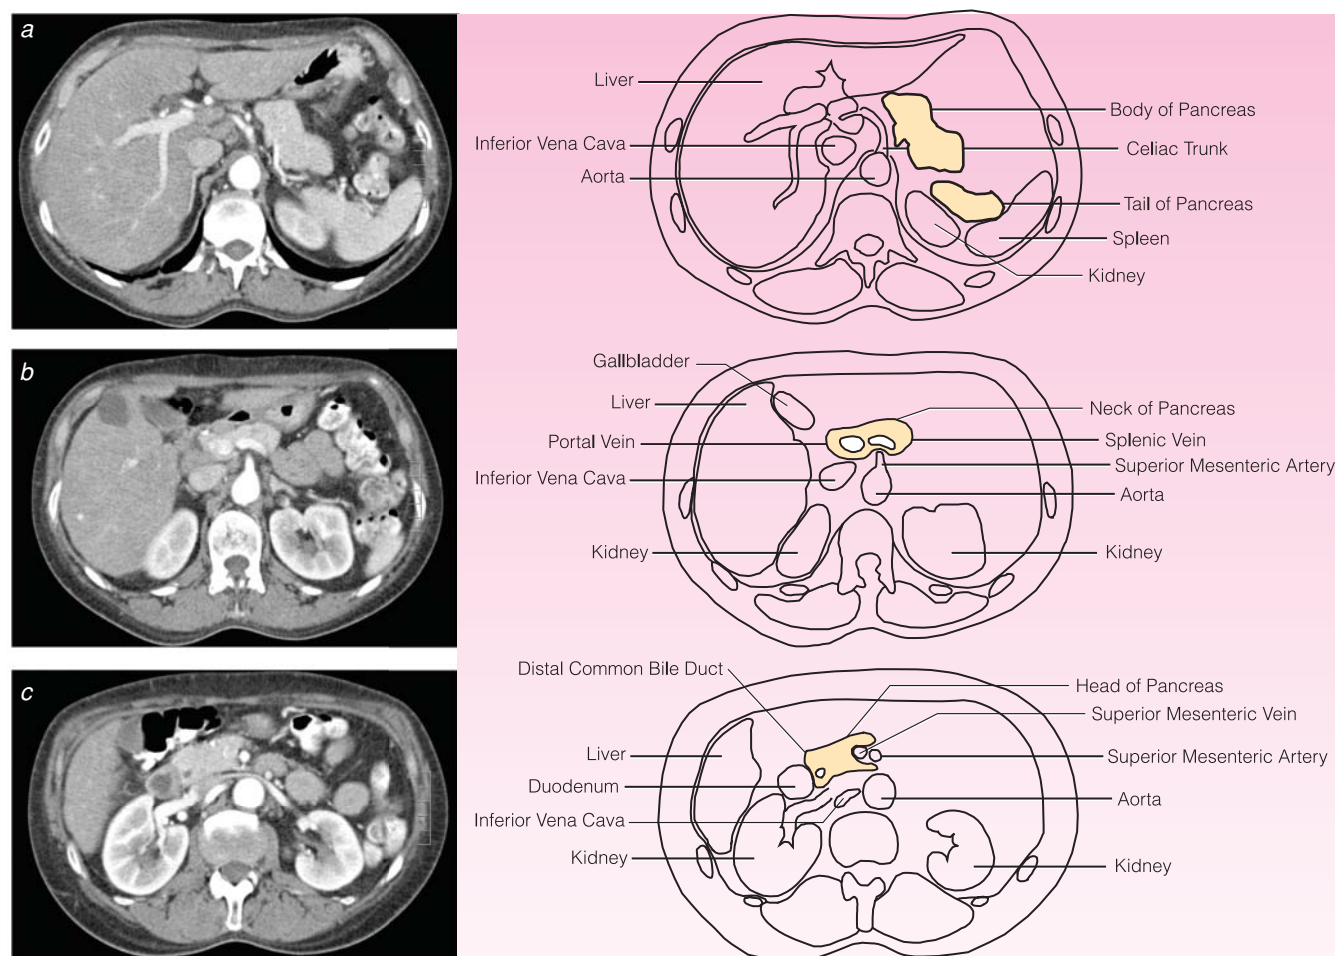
Computed tomography scans of normal pancreas. (a) Pancreatic body and tail. (b) Pancreatic neck. (c) Pancreatic head and uncinate process (demonstrating plane surrounding superior mesenteric artery and the inferior pancreaticoduodenal artery).
